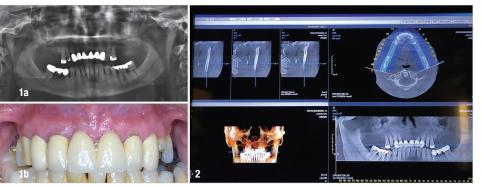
Panoramic radiograph of the initial situation. Fig. 1b: Patient before treatment. Fig. 2: CBCT scan of pre-op situation.
